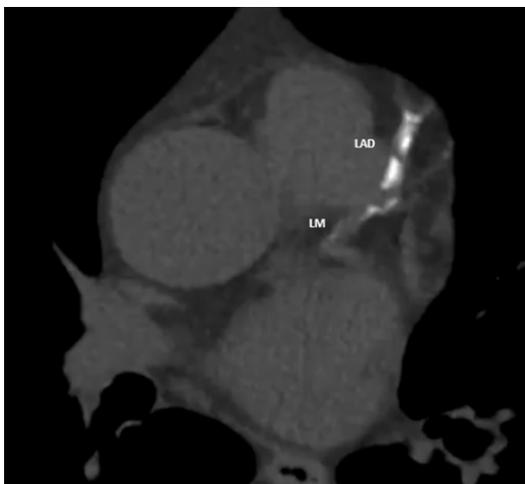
CT Coronary artery Calcium at the LAD (total =1,288 Agatston score).
